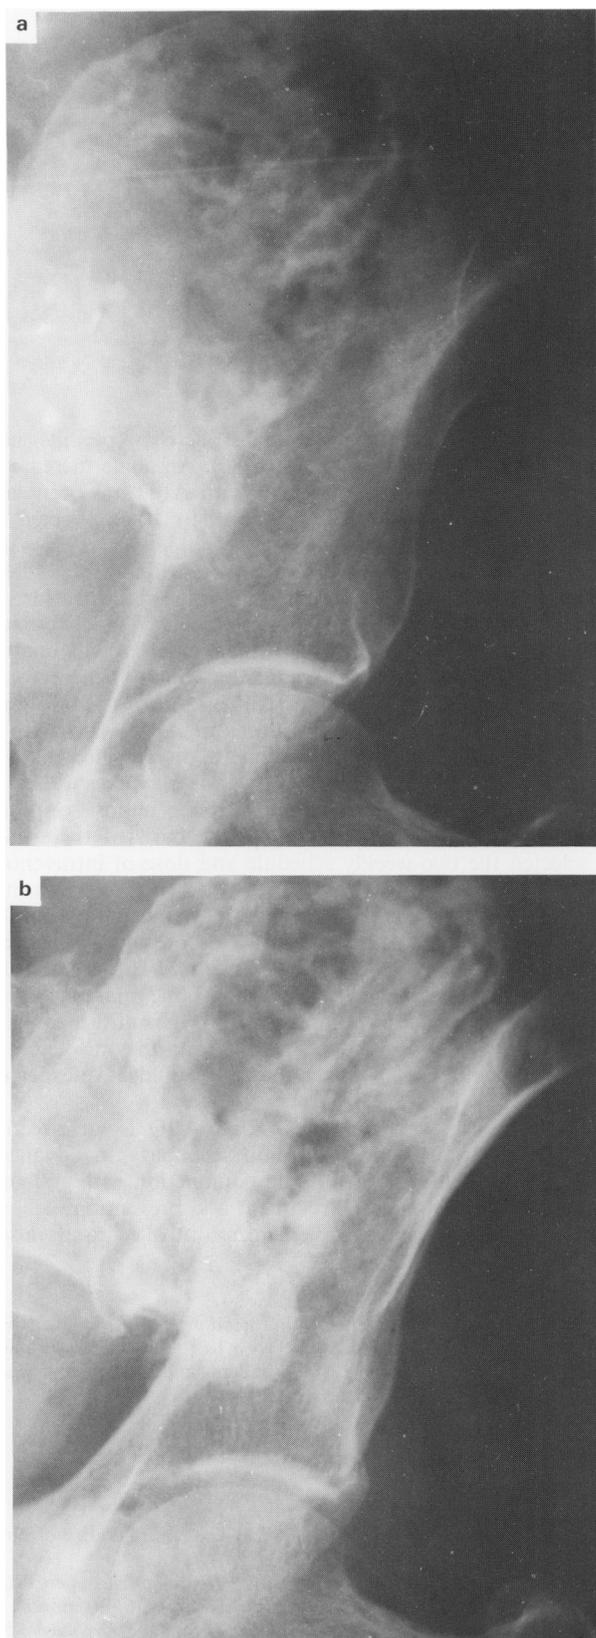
Plain radiographs of the left ilium (a) before and (b) 6 months after treatment with APD. The lytic areas in the ilium have undergone sclerosis.
